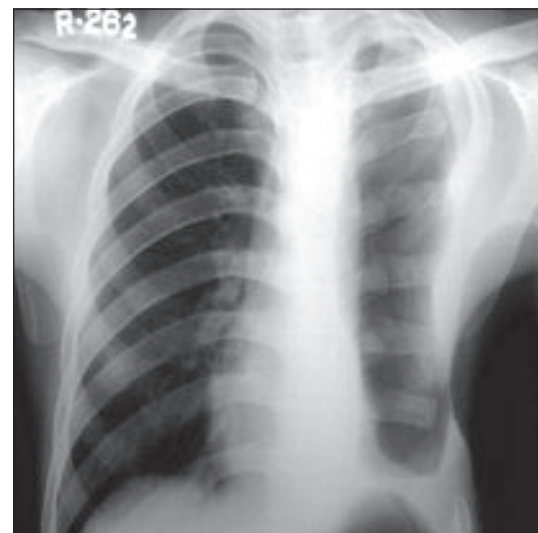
Chest x-ray after thoracoplasty of left hemithorax.
